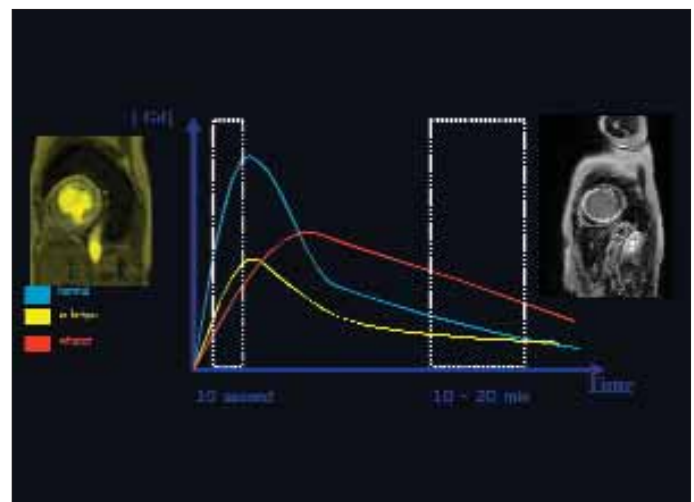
Time course of Gadolinium-chelate during delayed enhancement cardiac magnetic resonance imaging
